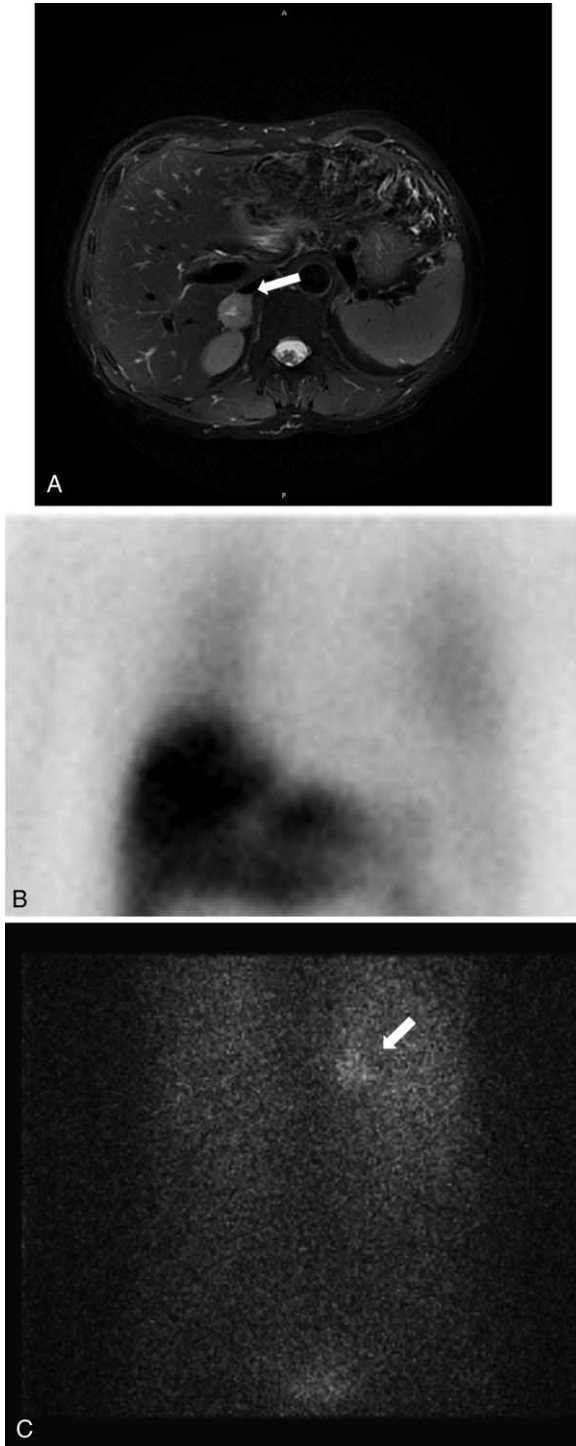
(A) Magnetic resonance imaging (MRI): mass in the right adrenal gland (3 × 2 cm) with the presence of necrotic areas. (B) Thorax scintiscan with 123-I metaiodio benzilguanidine (123-I-MIBG) showed a severely reduced MIBG cardiac uptake, with a heart to mediastinum (HM) ratio of 1.38. (C) Scintiscan with 123-I metaiodio benzilguanidine (123-I-MIBG) shows raised activity within the right adrenal gland.
